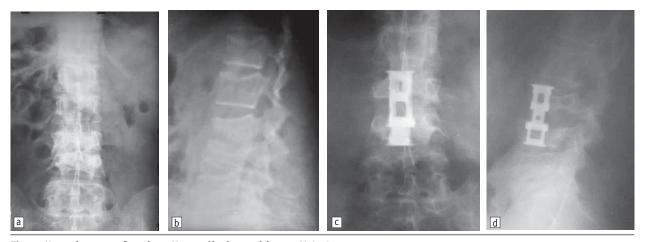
X-ray images of patient K., medical case history N 258
